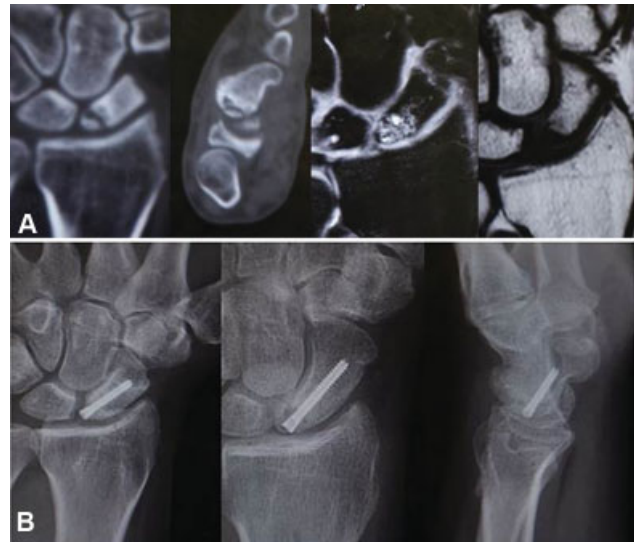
(A) Preoperative computed tomography and magnetic resonance imaging of a 48-year-old man with a 2.5-year-old proximal pole scaphoid nonunion and avascular necrosis. (B) One year postoperative radiographs of the same patient show union of the proximal pole. Patient remained asymptomatic through 153 weeks of postoperative follow-up.
